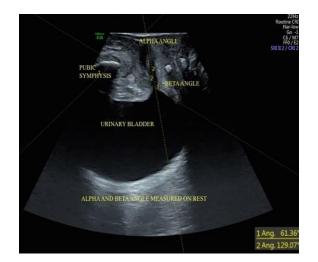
α and β angles measured by transperineal ultrasonography during rest.
